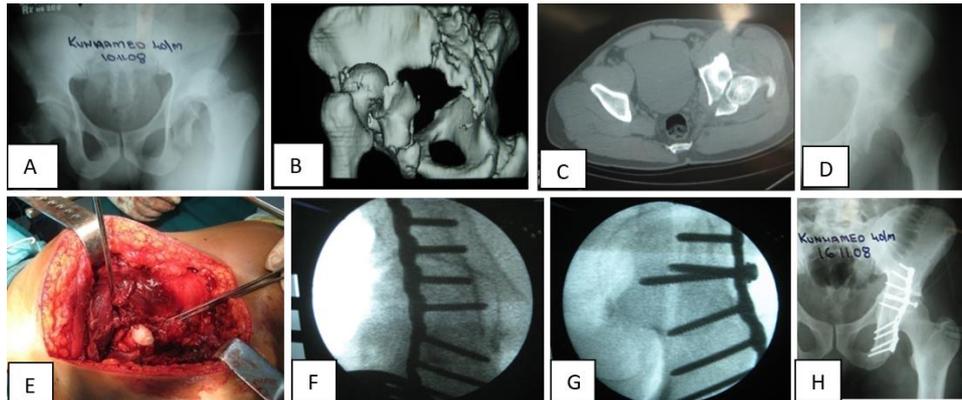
A: X ray pelvis with both hips- dislocation left hip with Posterior column fracture. B, C: CT scan shows posterior dislocation with posterior column fracture of left hip. D: Patient underwent emergency reduction of left hip. Post reduction x ray. E: Posterior column was fixed through Koher -Langenbeck approach. F, G: Intra operatively joint penetration of hard ware is ruled out by taking AP and oblique views of the hip using C arm. H: Post-operative x ray.
